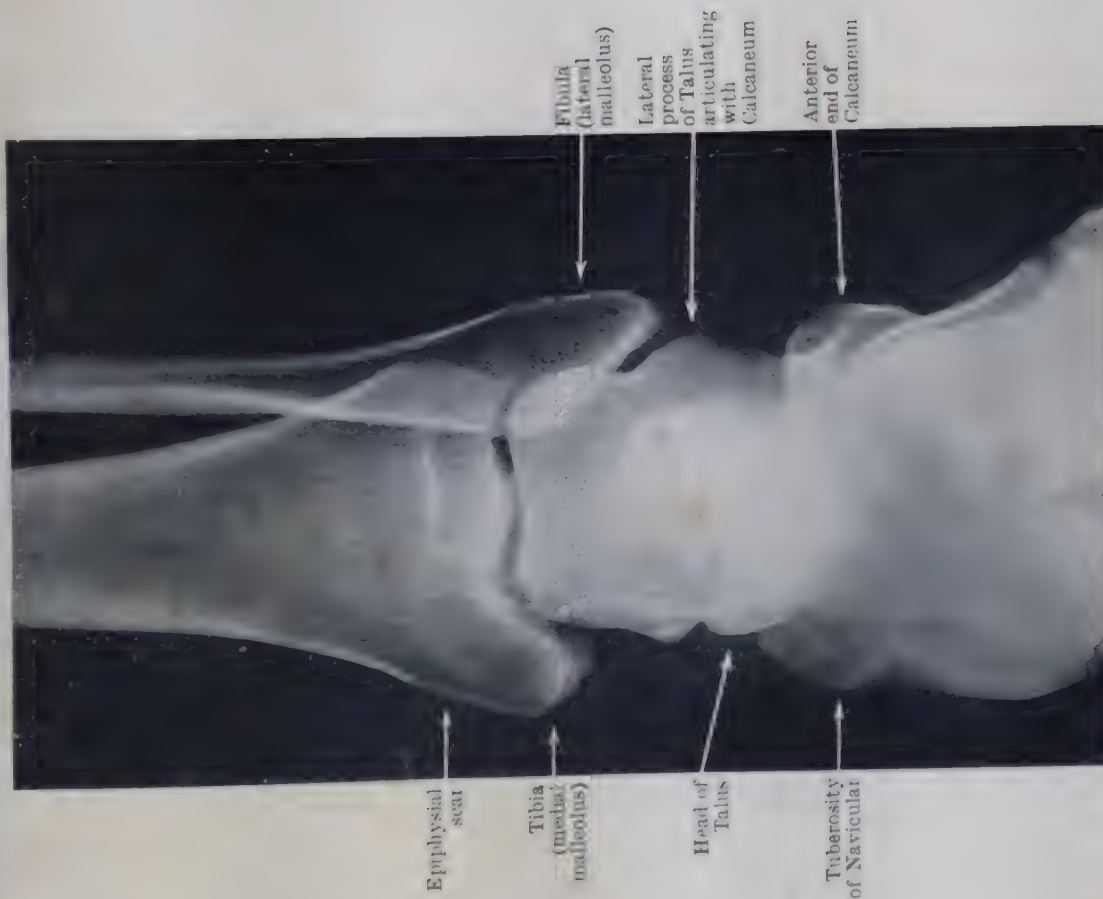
POSTERIOR RADIOGRAPH OF ANKLE AND TARSI OF YOUNG MAN AGED 22. (Dr. J. Duncan White.) Note that the superimposition of the shadows of the tarsal bones makes it difficult to distinguish them.
